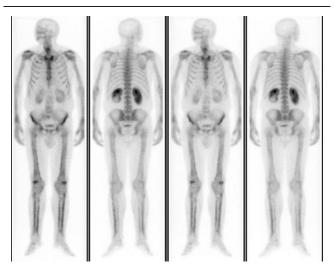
Bone scintigraphy showing diffuse hypercaptation of the radiopharmaceutical along the cortical of the long bones.
